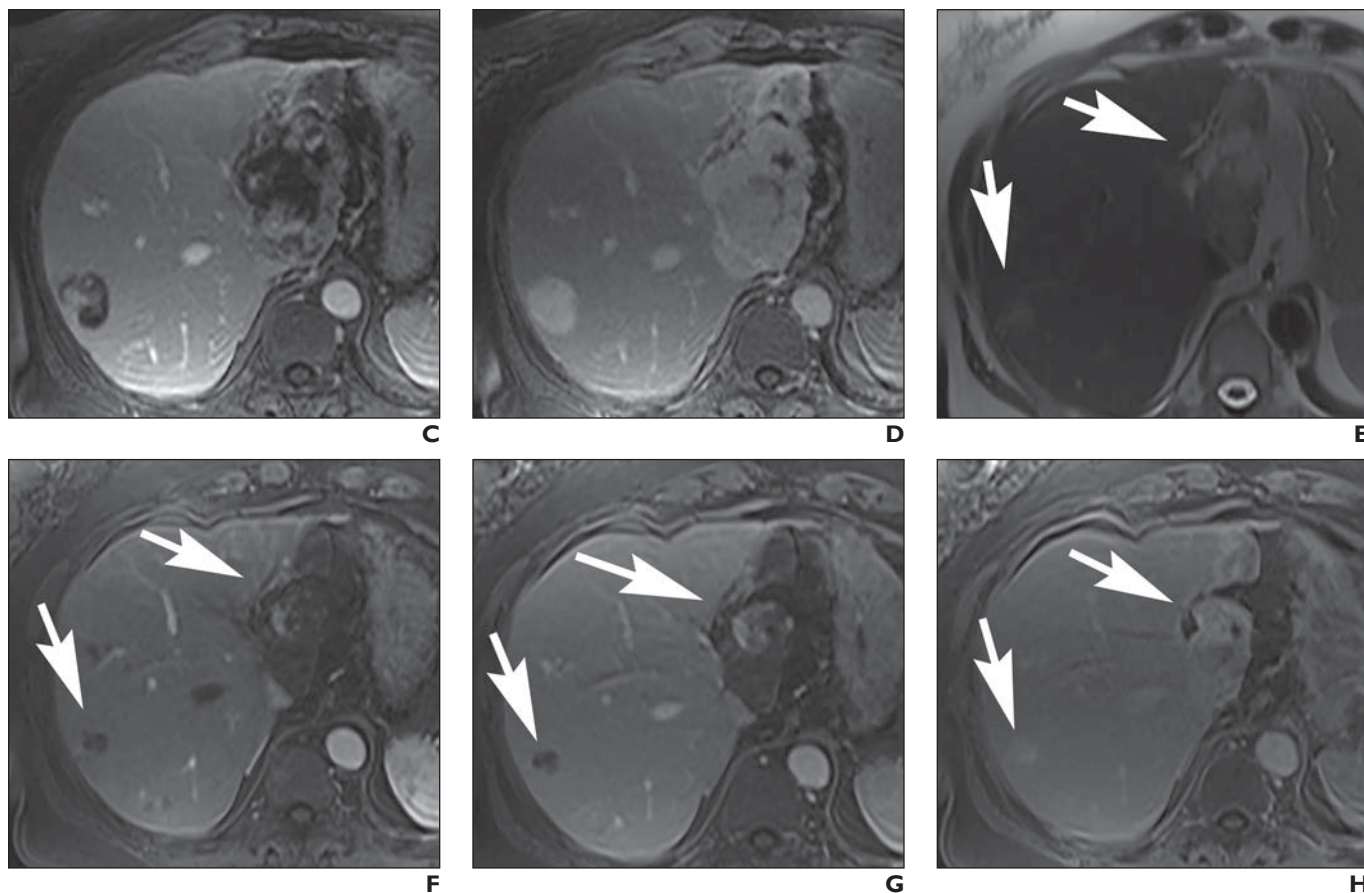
(continued)—57-year-old woman with nonalcoholic fatty liver disease. Example of hyalinized hemangioma. Initial images (A–D) show one lesion present in segment VI and one exophytic lesion arising from segment IVB in porta hepatis. Segment VI lesion has high signal intensity on T2-weighted image (A), whereas exophytic lesion is more complex, with areas of lower signal intensity in its periphery and interspersed in its center. Both lesions had diminished signal intensity on T1-weighted images (not shown) and nodular interrupted peripheral enhancement with centripetal filling on later phase contrast-enhanced images (B–D). Four years later (E–H), changes likely related to hyalinization of hemangiomas are present. Both lesions (*arrows*, E–H) are smaller than earlier examination (A–D), less well defined, have lower signal intensity on T2-weighted images, and have less classic enhancement pattern on early phases after contrast material administration (F and G) with filling in on 5-minute delayed phase image (H).
